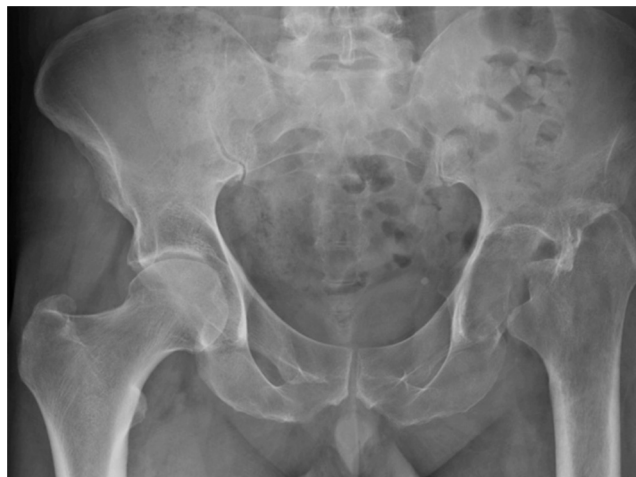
X-ray of the pelvis, with weight bearing (AP view).
